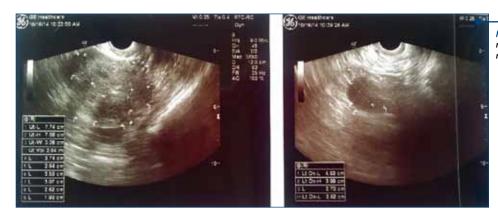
Transvaginal ultrasound: myomas of uterus with a thick endometrium and cyst on right ovary
